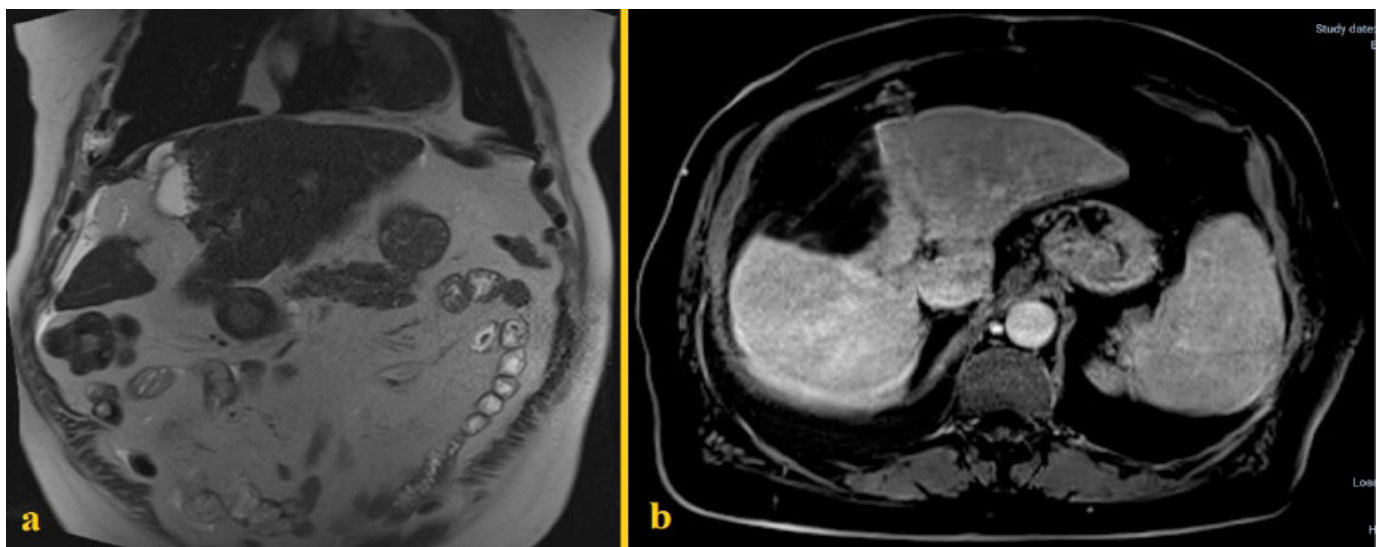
Hepatobiliary specific contrast enhanced magnetic resonance image study performed 3 months after the robotic central hepatectomy disclosing no signs of recurrence. A) coronal plane; B) axial plane.
